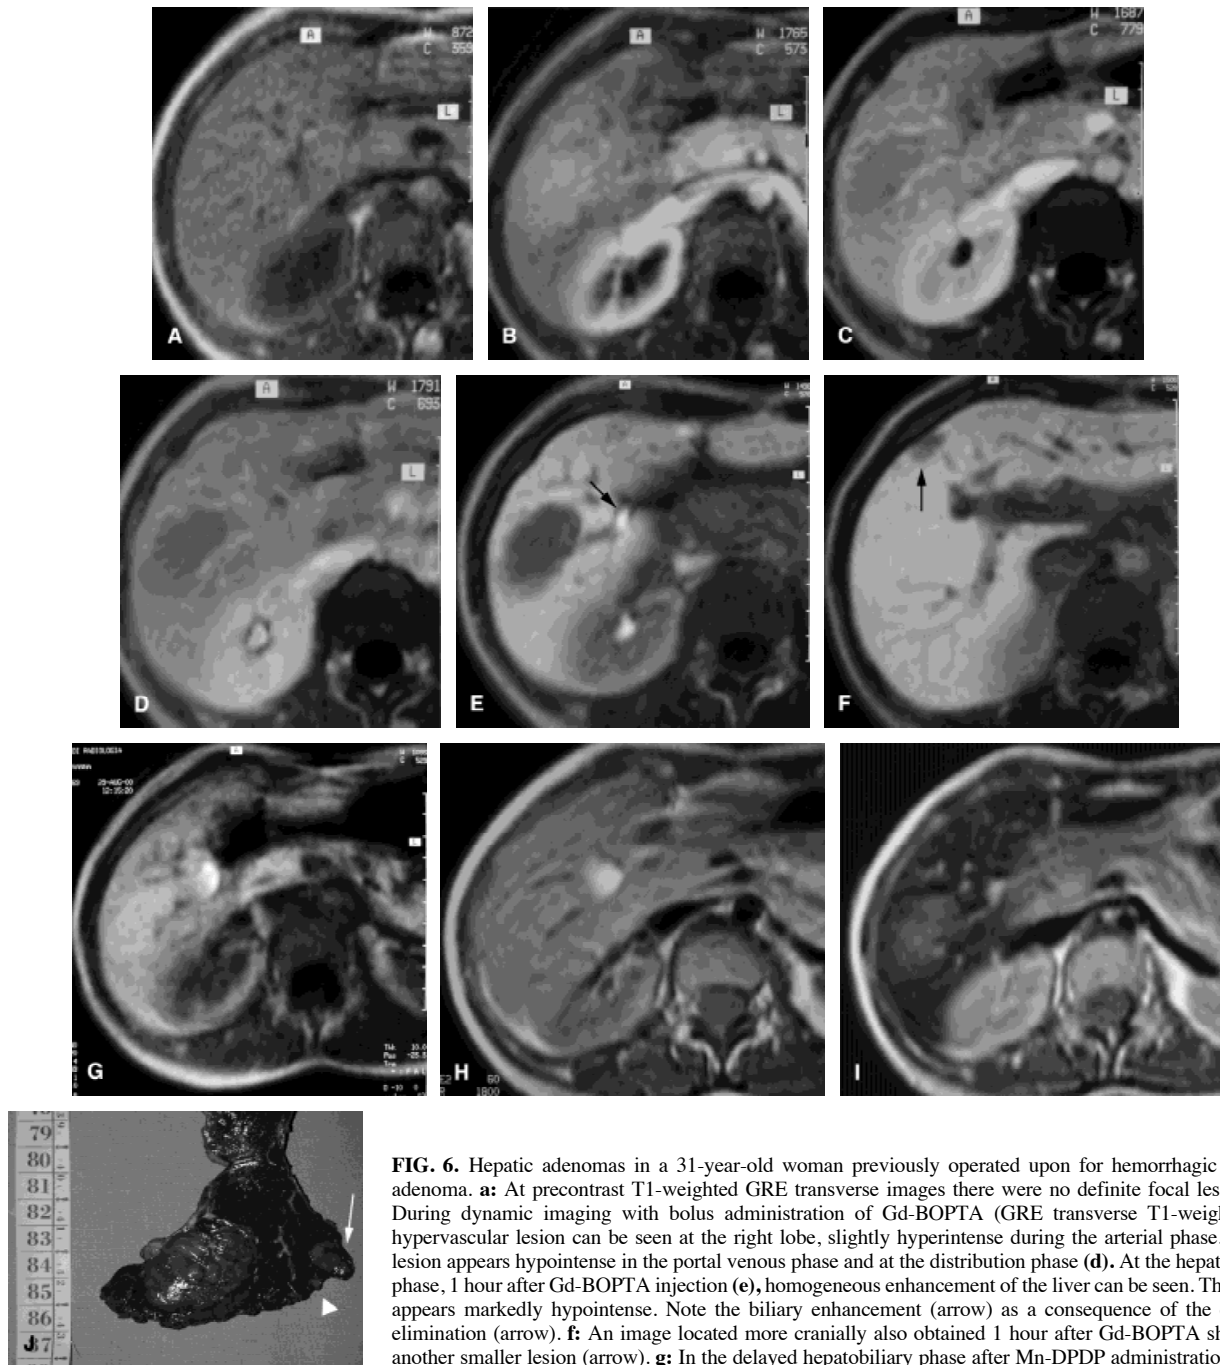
Hepatic adenomas in a 31-year-old woman previously operated upon for hemorrhagic hepatic adenoma. a: At precontrast T1-weighted GRE transverse images there were no definite focal lesions. b: During dynamic imaging with bolus administration of Gd-BOPTA (GRE transverse T1-weighted), a hypervascular lesion can be seen at the right lobe, slightly hyperintense during the arterial phase. c: The lesion appears hypointense in the portal venous phase and at the distribution phase (d). At the hepatobiliary phase, 1 hour after Gd-BOPTA injection (e), homogeneous enhancement of the liver can be seen. The lesion appears markedly hypointense. Note the biliary enhancement (arrow) as a consequence of the contrast elimination (arrow). f: An image located more cranially also obtained 1 hour after Gd-BOPTA shows another smaller lesion (arrow). g: In the delayed hepatobiliary phase after Mn-DPDP administration (GRE transverse T1-weighted), the lesion appears slightly hyperintense to background liver. h,i: SE transverse
